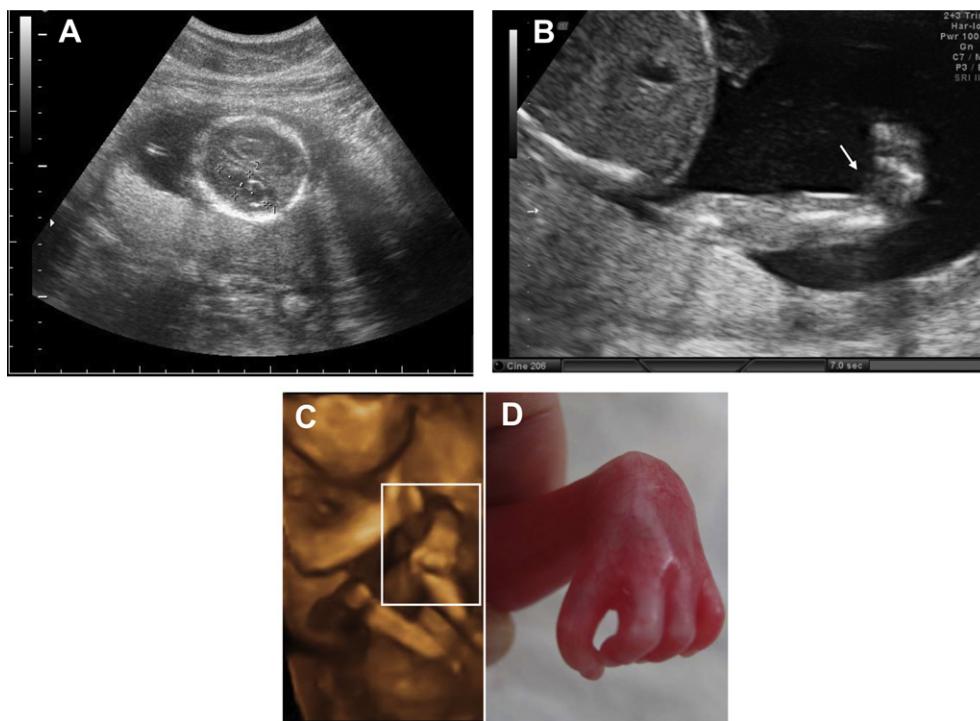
Prenatal ultrasound findings. (A) Choroid plexus cysts at 18 weeks of gestation. (B, C) Flexion contracture deformity of the left wrist with absence of the thumb (arrow and inset) at 22 weeks of gestation. (D) Corresponding findings for the left wrist and absence of the thumb at birth as compared with the three-dimensional ultrasound image in (C), inset.
